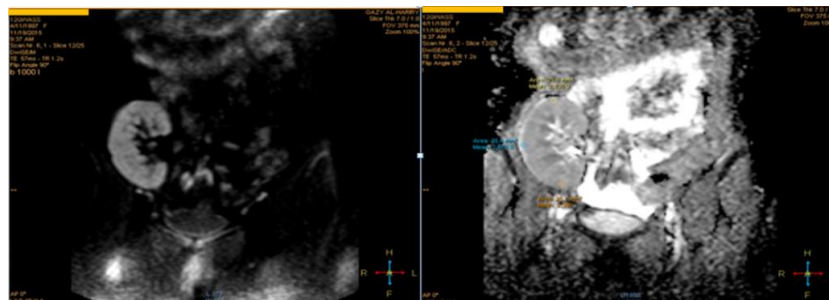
Coronal DWI and ADC for patient with stable or normal renal allograft function, the ADC map showing homogenous pattern with high mean ADC values of the renal parenchyma.
